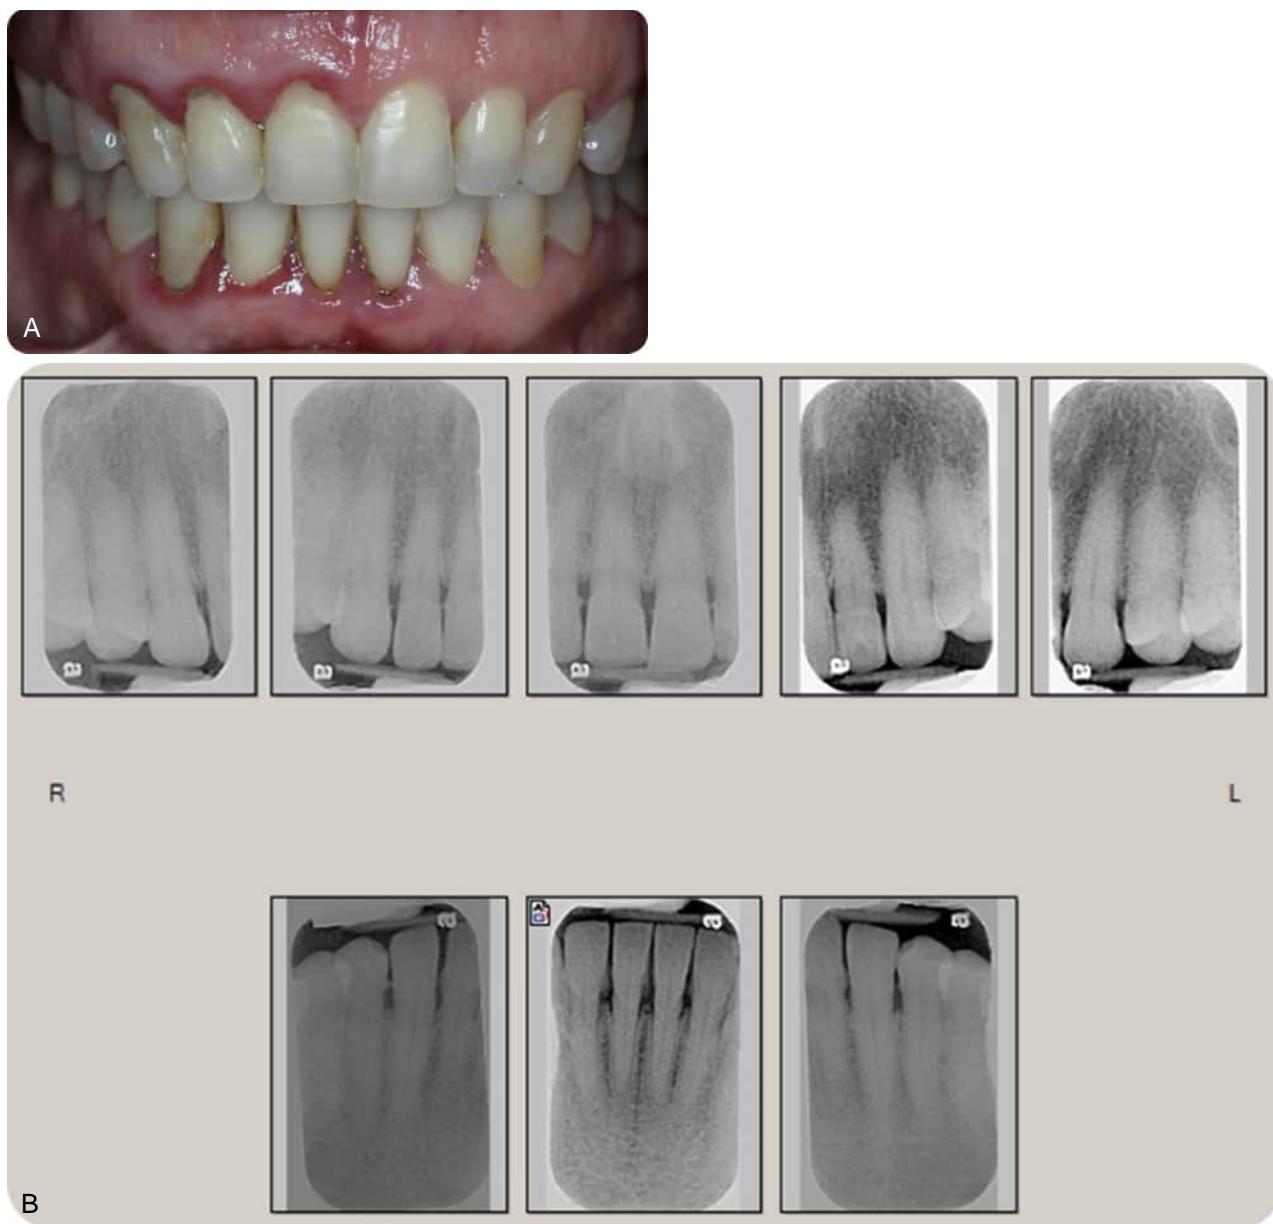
(A) Clinical presentation of stage II periodontitis. (B) Radiographic presentation of stage II periodontitis.
